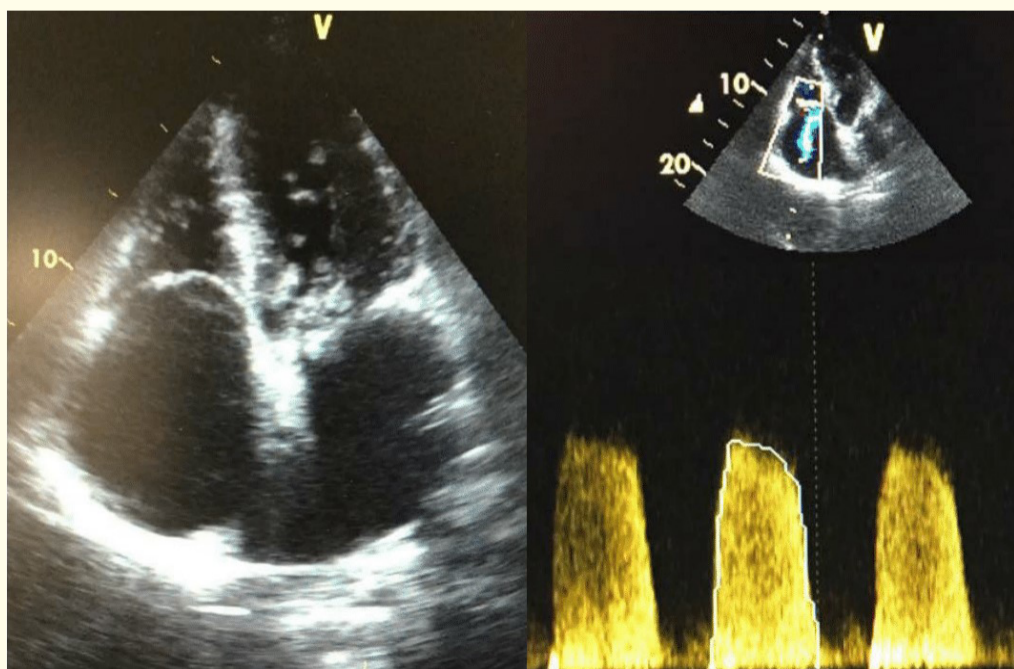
TTE apical 4 chamber view showing significant tricuspid stenosis ($MDG = 19 \text{ mmHg}$) and moderate regurgitation.
